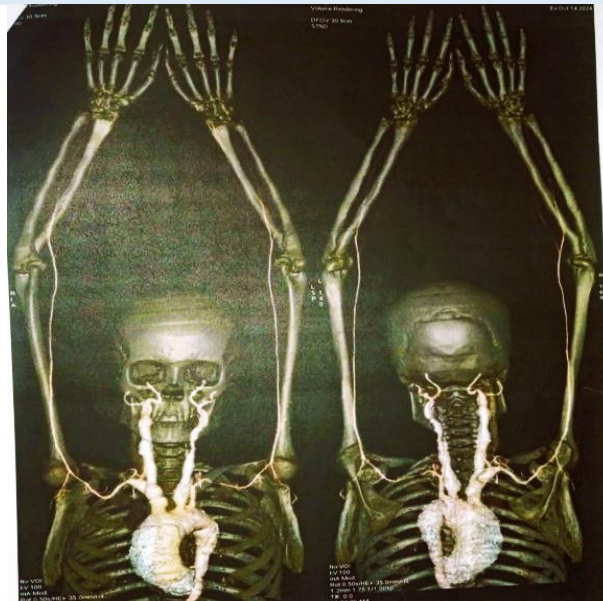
CT angiogram of both upper limb vessels showed Irregular narrowing and dilatation in both common carotid artery, mild aneurysmal dilatation of the brachiocephalic trunk and right proximal subclavian artery.
